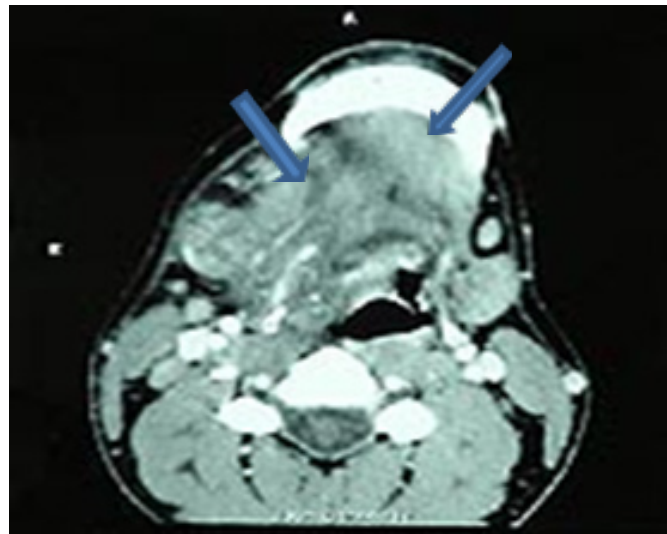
CT of the neck revealed thickening and inflammation of tongue, and floor of the mouth, compression of hypopharynx due to swelling of right lateral pharyngeal space.
